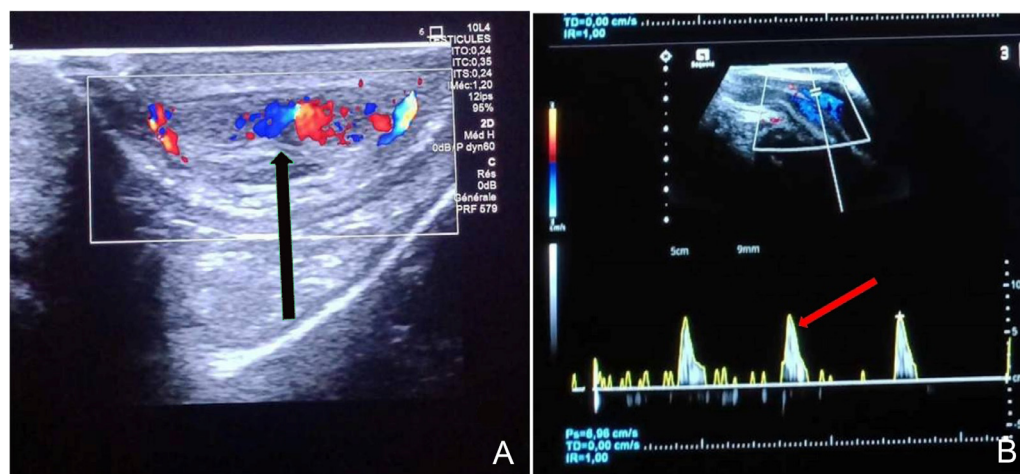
Color ultrasound Doppler shows an abnormal increased color flow in focal zone of the left corpora cavernosa and adjacent soft tissues (black arrow) (A). (B) Dilated vascular lake with turbulent flow and high flow velocity characteristic of arteriovenous fistula with high peak systolic velocity, PSV = 9.3 cm/sec (red arrow).
